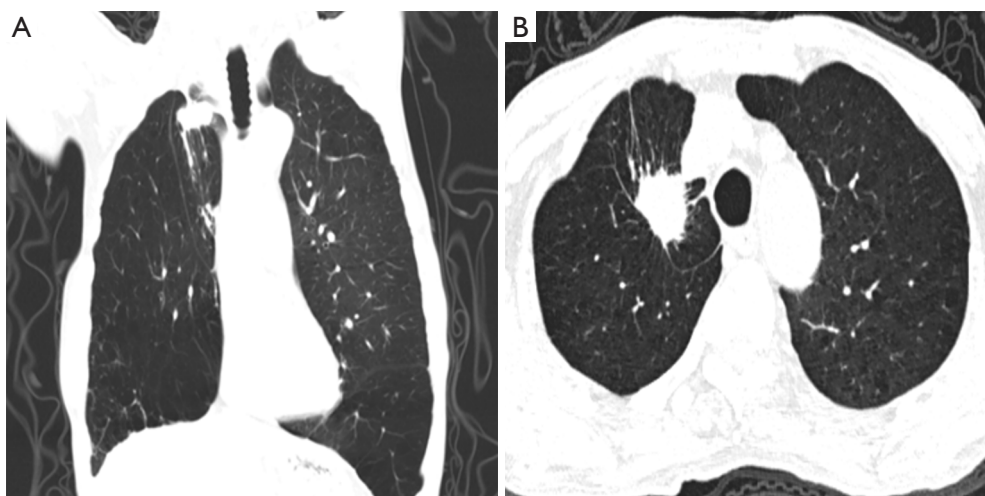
CT showed a well-defined irregular, lobulated nodule (25 mm × 26 mm) in the upper part of the remaining right lung with pleural traction. CT, computed tomography.
